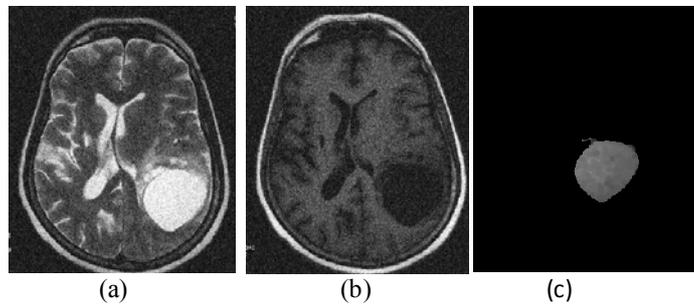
shows the example for checking performance of AGASA on Rician noise added images of 20dB SNR (a) T2- weighted (b) T1- FLAIR (c) segmented tumor
